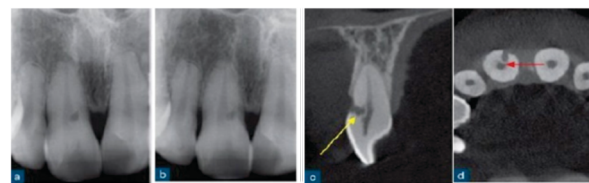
External cervical resorption (ECR). (a and b) Parallax radiographs of the maxillary left central incisor reveal a radiolucency in the coronal third of the root canal. (c) Reconstructed sagittal and (d) axial CBCT slices confirm the presence and true extent of the ECR lesion.
